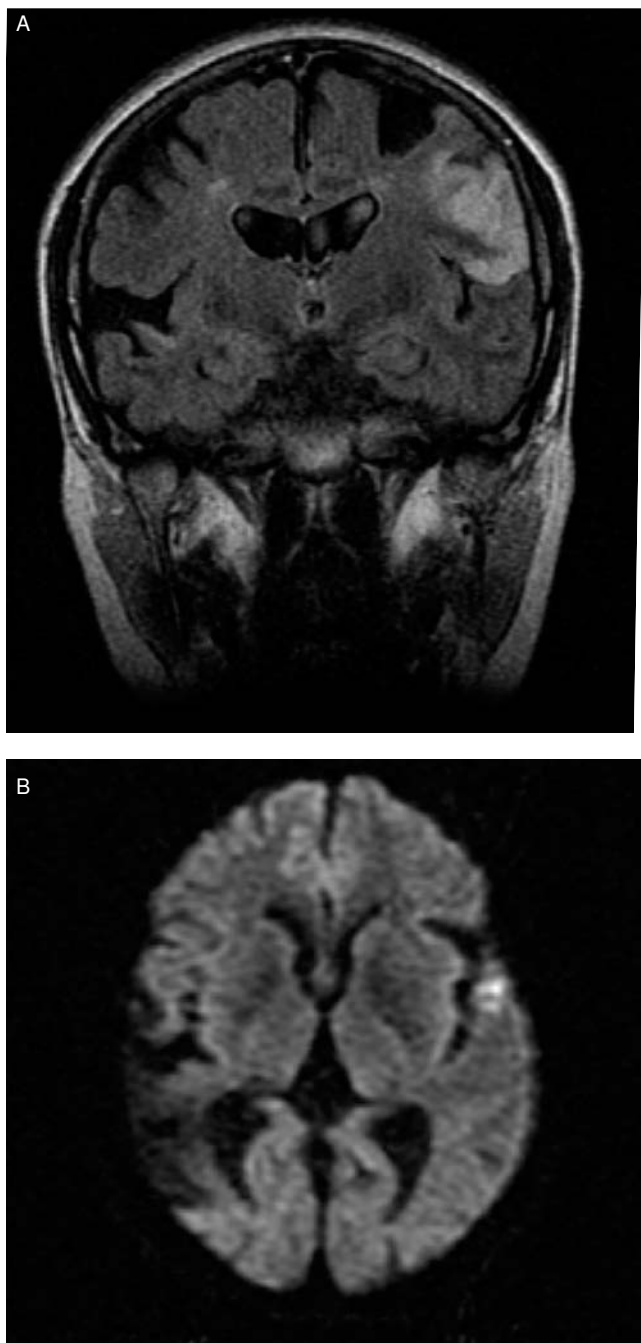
Brain MRI. A: coronal cut in FLAIR sequence showing signal hyperintensity at the level of the left frontal operculum. B: axial cut in diffusion sequence showing hypointensity at the right parietooccipital level that affects the right operculum and hyperintensity at the level of the left operculum indicative of right chronic ischemic lesion and left acute ischemic, respectively.
